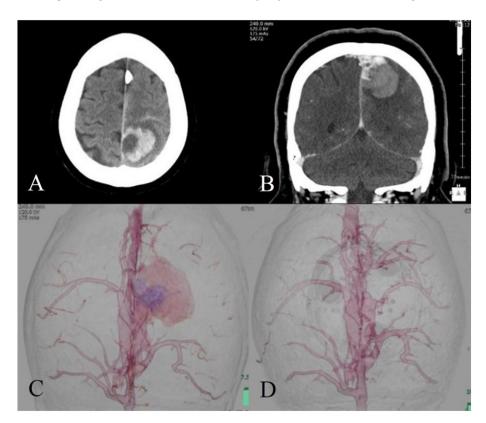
Radiological findings of the patient are shown. Plain brain CT on axial section shows the hemorrhagic mass adjacent to the superior sagittal sinus (Fig. 1A). Enhanced brain CT on coronal section shows the enhancement of the superior sagittal sinus and a part of the tumor (Fig. 1B). Fig. 1C and D show the 3-dimensional CT angiography before and after the surgical resection.
